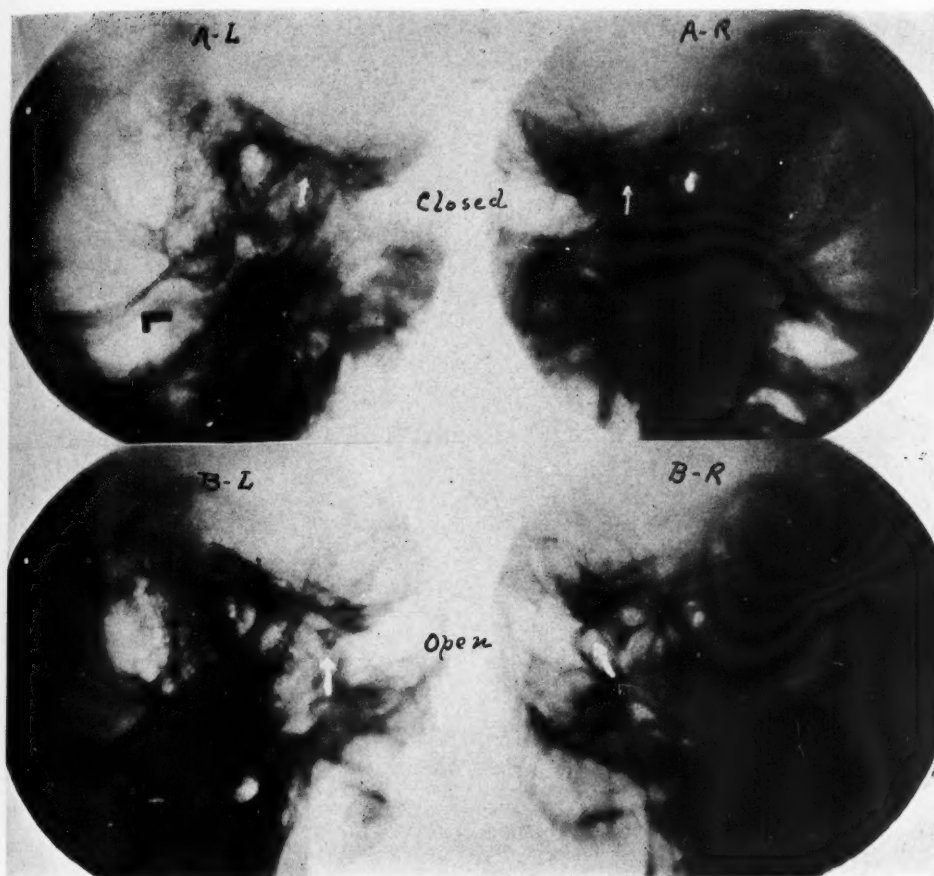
The mandibular joint with arthritic changes to the extent of partial or complete ankylosis. Case 2, Mr. K., aged 35. *Clinical Symptomatology*.—Crackling noise and sharp boring pain within the left ear for past two years, and stiffness of jaw movements since forceful reduction procedure for malocclusion at the age of 12. Pain radiates to zone about the left eye. *Roentgenological Findings*.—Hazy joint outlines, increased on the left; face of condyle flattened; glenoid fossa angulated by erosion; joint space extremely narrow. *Treatment*.—Full mouth reconstruction by thin overlays on natural teeth, extend vertical molar dimension on left. A-L, Closed position, left mandibular joint; A-R, Closed right mandibular joint; B-L, Open left mandibular joint; B-R, Open right mandibular joint.
